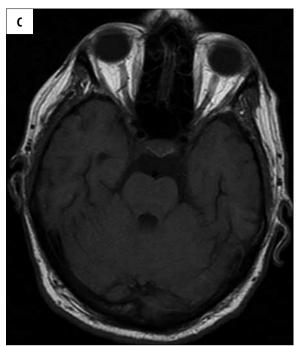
C. Brain MRI. SE/T1-weighted images. Countless, tiny, weakly hyperintense foci disseminated in the meninges, supratentorial compartment and cerebellum.
